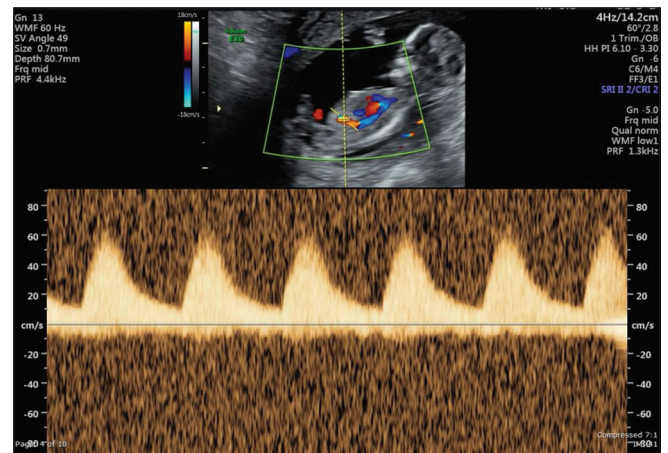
Ultrasound with spectral Doppler in sagittal view. A large single umbilical artery was seen continuing in an anterior direction toward the umbilical cord, showing arterial waveform on spectral Doppler
